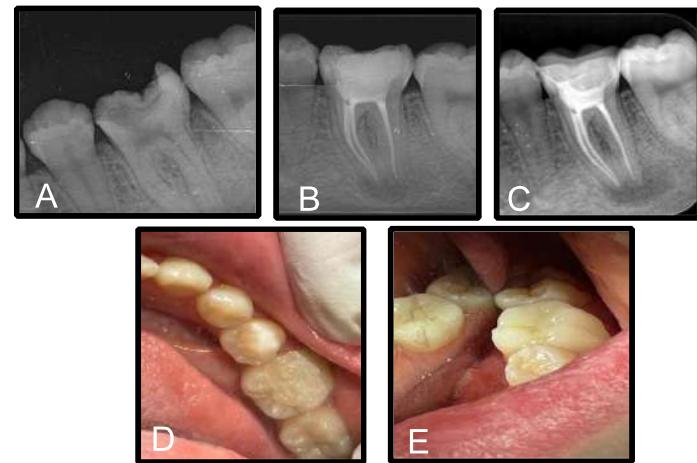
A: Pre-operative radiography. B: Post-operative radiography C: After cementation radiography. D: Intraoperative preparation E: After intraoperative cementation
